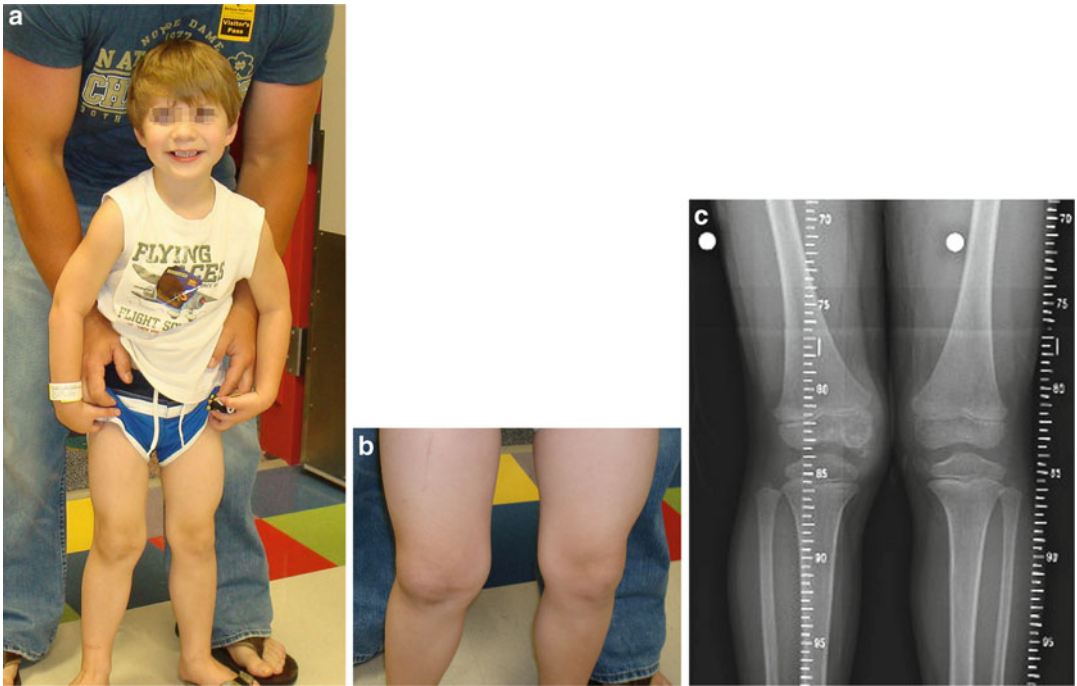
(a–c). A 5-year-old boy (a) was seen because of swollen right knee with complaint of knee pain and limping. Note the swelling of the medial aspect of the right knee (b). The knee radiograph (c) shows second ossification center merged with the medial aspect of the epiphysis of the right distal femur
